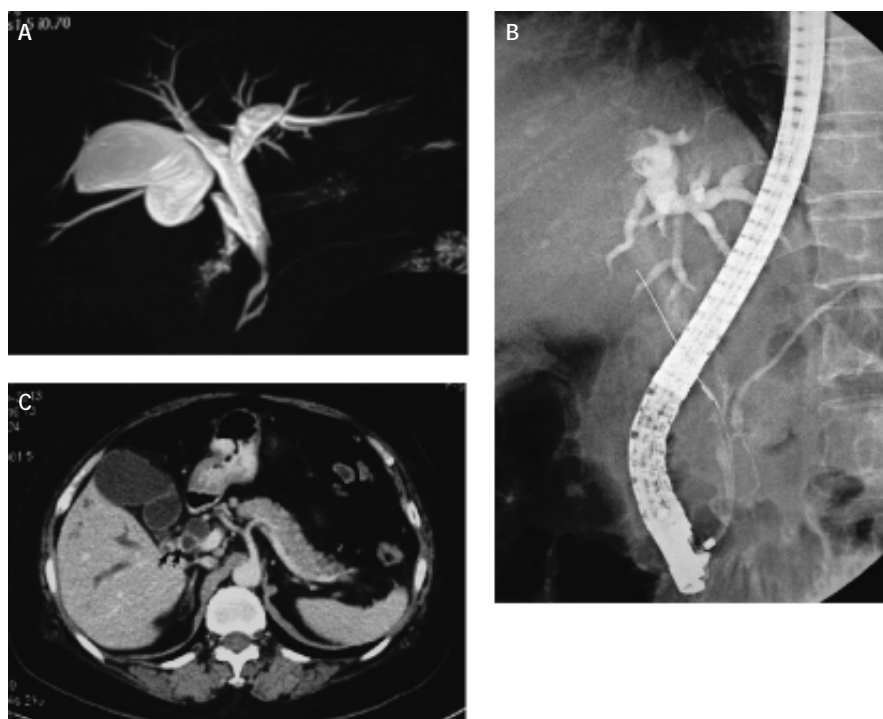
No. 9 patient, F/69, diagnosed as type IVa congenital choledochal cyst with abnormal pancreatic biliary duct two years ago, as shown in MRCP image (A). The patient was admitted to our institution due to fever and jaundice. ERCP (B) showed an obvious dilation of intrahepatic bile duct; (C) CT manifested thick, abnormally enhanced wall of extrahepatic bile duct as well as cystic duct (arrow). An exploratory surgery and biopsy revealed adenocarcinoma of distal bile duct.
